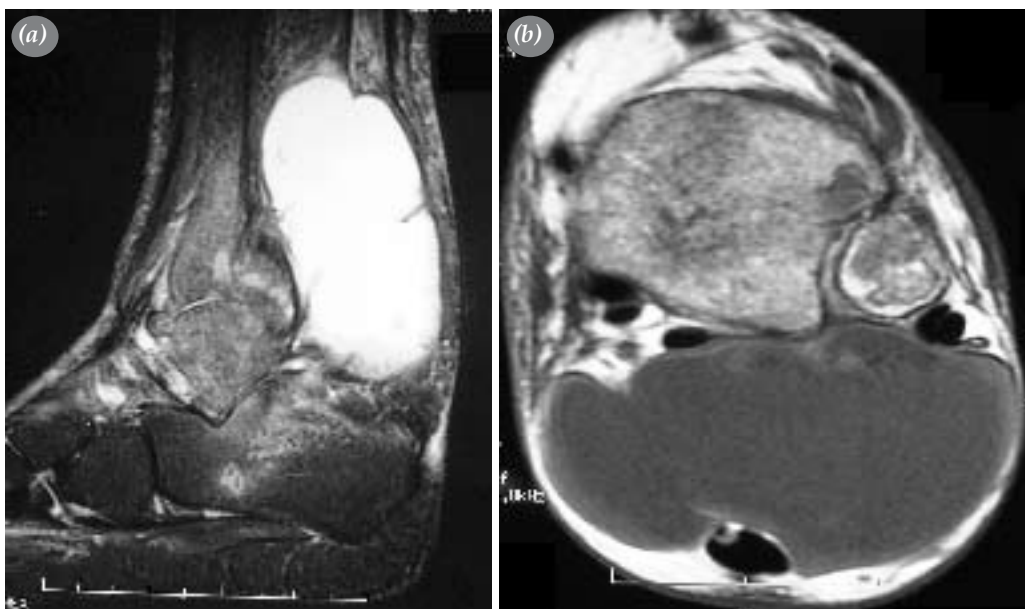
Magnetic resonance imaging of the ankle. (a) Sagittal T_2 -weighted image demonstrating a cystic collection on the achilles tendon. (b) Axial T_2 -weighted image, near to the ankle level, revealing the achilles tendon surrounded by the cystic collection.
